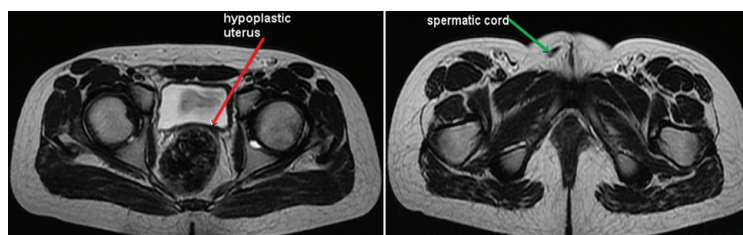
Magnetic resonance imaging showing rudimentary uterus (red arrow) and right side spermatic cord (green arrow).
